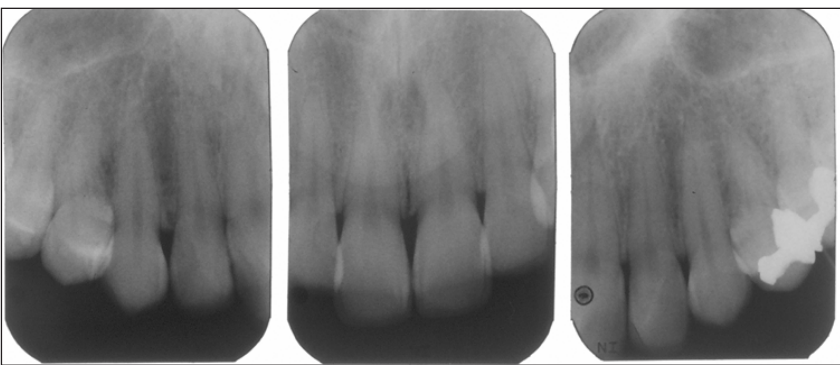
X-ray finding 20 years after PLVR. All restored teeth were intact and vital.
